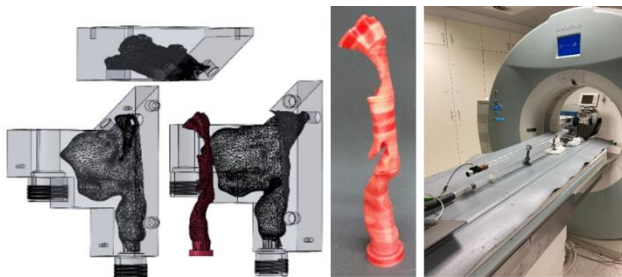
Explosion view of the casting mold with integrated soft tissue and water-soluble airway (left), 3D printed water-soluble airway (middle) and measurement setup in the CT scanner (right).
